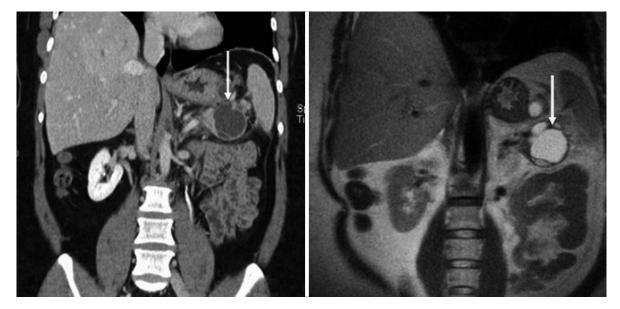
Coronal reformatted image of endoscopically proven pseudocyst based on analysis of cyst fluid at aspiration. Coronal reformatted CT image (*left*) and coronal single shot fast spin echo MR image (*right*) shows pseudocyst (*arrow*) in the tail of the pancreas. Similar information is obtained without the use of radiation at MR imaging
